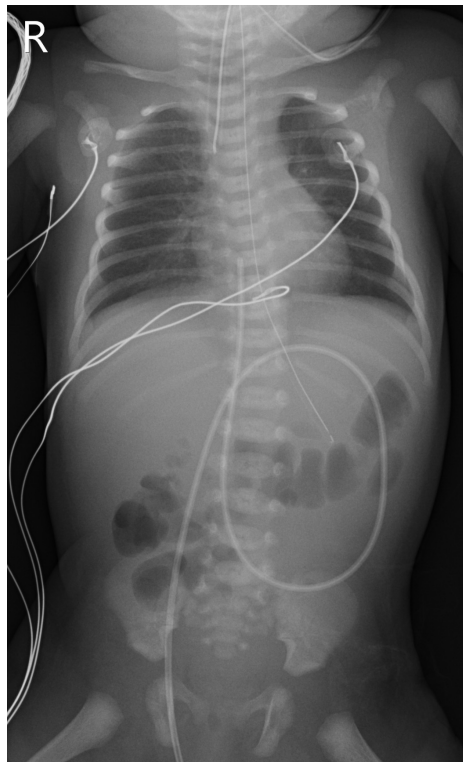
X-ray showing open-airy lungs with non-specific parenchymal changes. Adequate lung volume.
